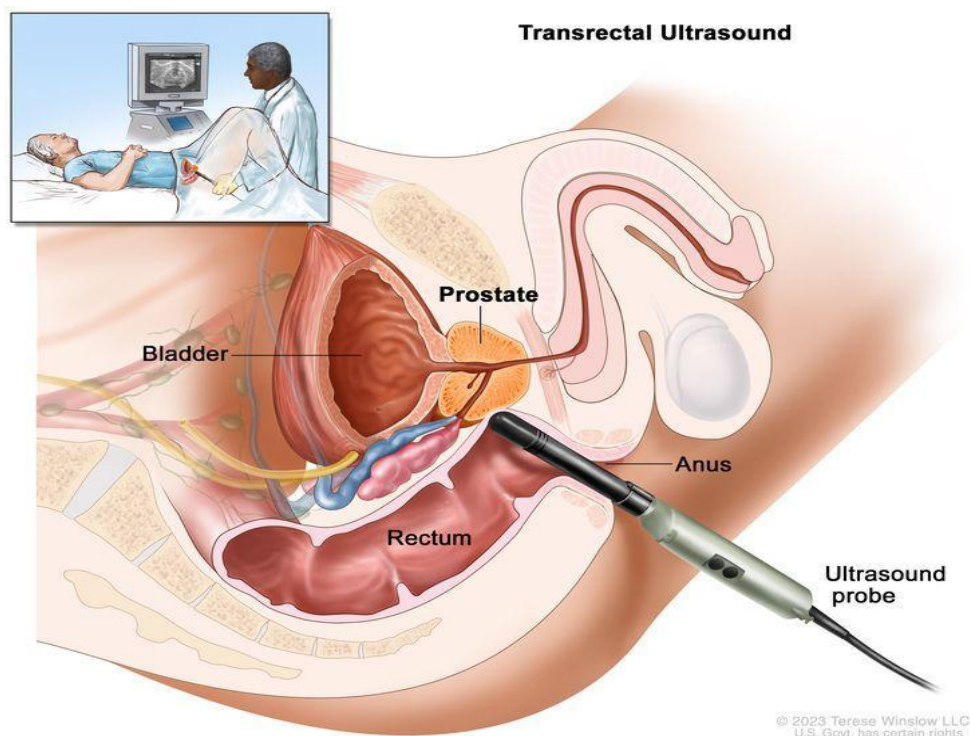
Transrectal ultra sound. An ultrasound probe is inserted into the rectum to check the prostate. The probe bounces sound waves off body tissues to make echoes that form a sonogram (computer picture) of the prostate [21].
